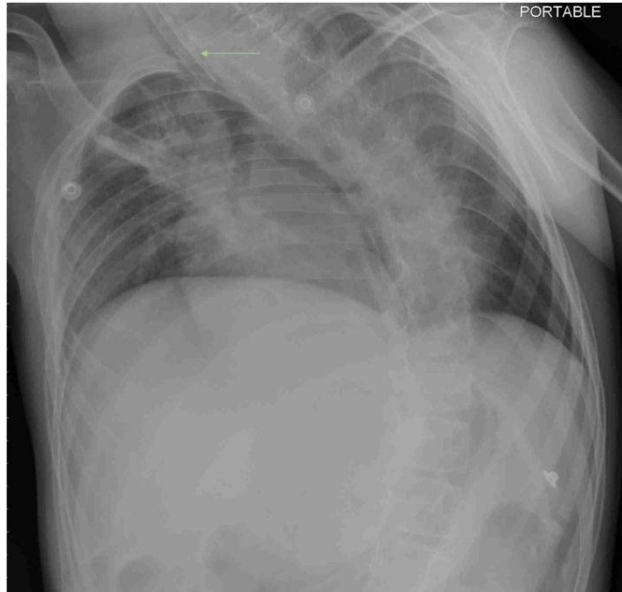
Chest X-ray post-endoscopic removal of the NPA. Green arrow point to the ETT in place.
